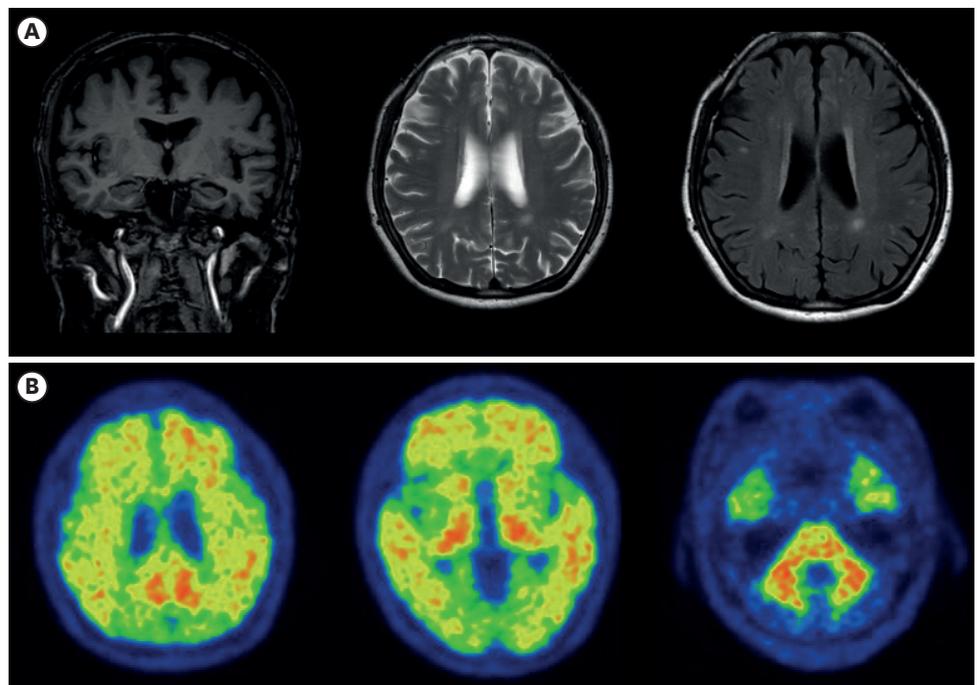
Neuroimaging of Patient 1. Brain MRI showed (A) minimal global brain atrophy, hippocampal atrophy score of 1 on the right and 2 on the left based on the Scheltens’ scale¹¹ and grade 1 periventricular and grade 1 deep white matter hyperintensities based on the Fazekas scale.¹² F-18 Flutemetamol positron emission tomography computed tomography showed (B) abnormal accumulation of β -amyloid plaque in mainly bilateral frontal lobes, posterior cingulate gyri, precuneus, and left lateral temporal lobe.
